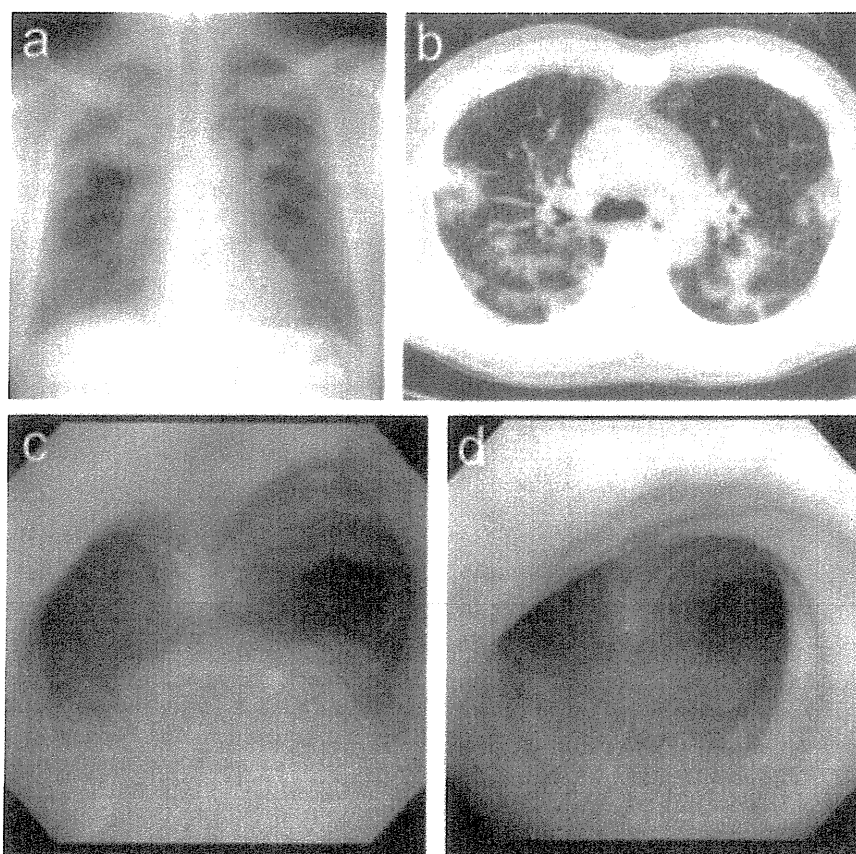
Radiological and bronchoscopic findings in Case 2. (a) Chest radiograph at admission showing bilateral consolidations in the upper lung fields. (b) Computed tomography of the chest at admission showing bilateral consolidations in the middle lung fields and periphery. (c) Multiple whitish nodules on the tracheobronchial mucosa, as revealed by fiberoptic bronchoscopy five days after admission. (d) Disappearance of the tracheobronchial nodules 21 days after steroid therapy began.
